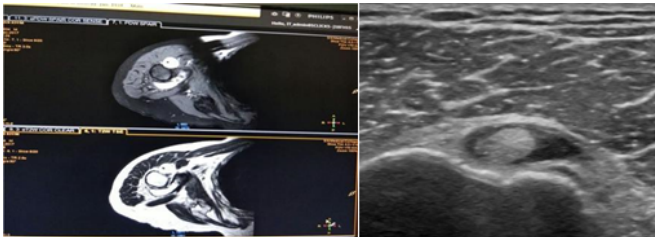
(a) MRI, PDW and T2 weighted images showing circumferential fluid collection around the long head of biceps tendon in bicapital groove. (b) USG images showing circumferential fluid collection around the long head of biceps tendon
